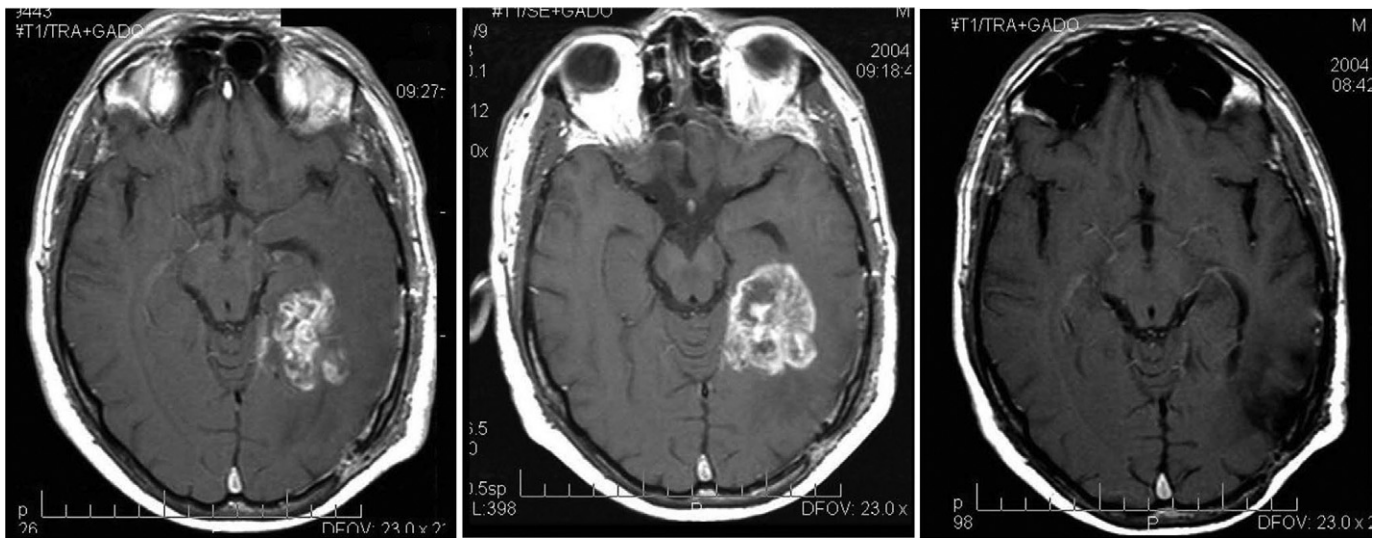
FIGURE Pseudoprogression after radiation with concurrent and adjuvant TMZ. A 65-year-old man who was diagnosed with a left frontal GBM underwent a gross total resection followed by 6 weeks of radiation with concurrent TMZ. From left to right: T1-weighted MRI with contrast after resection showing postsurgical changes; T1-weighted MRI with contrast after completion of radiation and TMZ showing increased contrast enhancement (center image); and T1-weighted MRI with contrast after completion of 6 cycles of adjuvant TMZ showing complete resolution of contrast enhancement supporting post-treatment changes as consistent with pseudoprogression.
